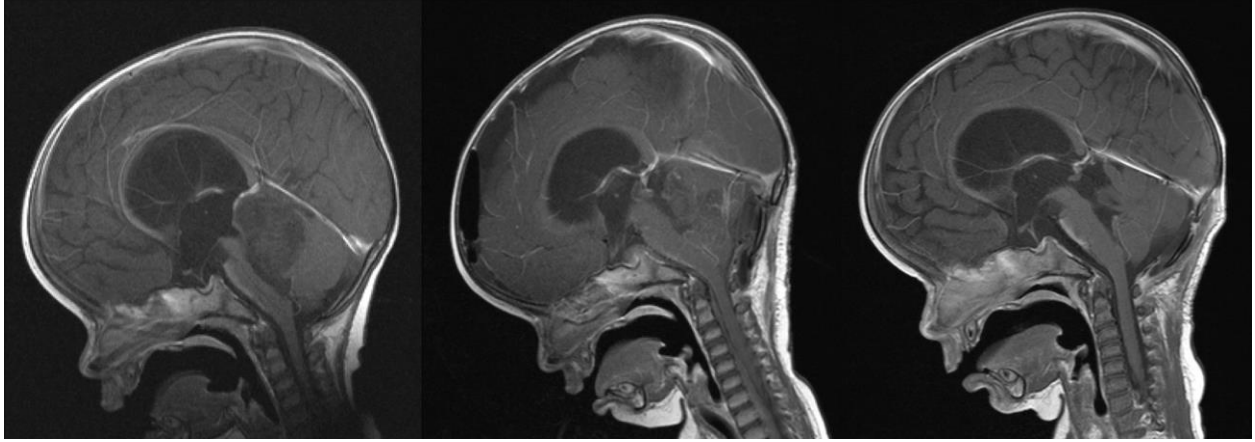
Ten month old girl with infratentorial heterogeneous non-enhancing atypical teratoid/rhabdoid tumor. Following gross total resection, she underwent chemotherapy according to a published protocol<sup>31</sup> involving Vincristine, Cyclophosphamide, Actinomycin, with subsequent high dose Carboplatin and Thiotepa and peripheral stem cell rescue. A, pre-operative scan. B, post-operative scan demonstrating gross total resection. C, surveillance scan at three years. All scans sagittal T1-weighted post-Gadolinium MRI.
